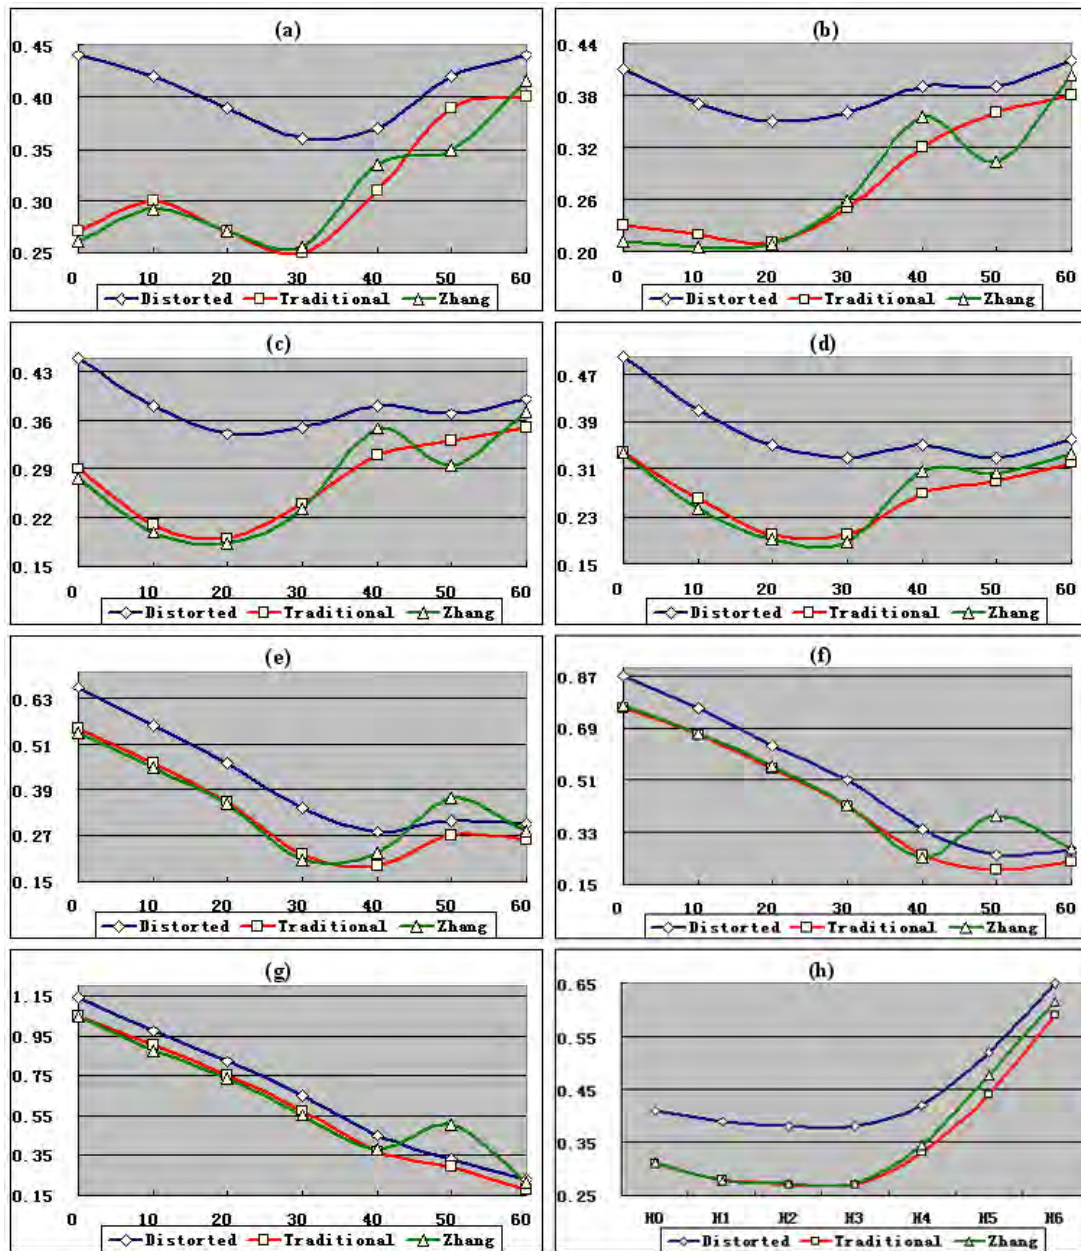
(a-g) shows the overlay-plane-errors for the X-ray and video images aligned by  $H_0$ ,  $H_1$ ,  $H_2$ ,  $H_3$ ,  $H_4$ ,  $H_5$ , and  $H_6$  respectively. The horizontal axis of (a-g) demonstrates the distance between the intensifier and the plane where the overlay errors have been estimated. (h) shows the overall-overlay-errors when applying the seven different homographies in our experiments. The horizontal axis in (h) represents the seven homographies. The vertical axis in all of the sub-figures shows the error in millimeter. The errors resulted by no distortion correction, traditional and Zhang's method are drawn by diamond, square and triangle separately in each image.
